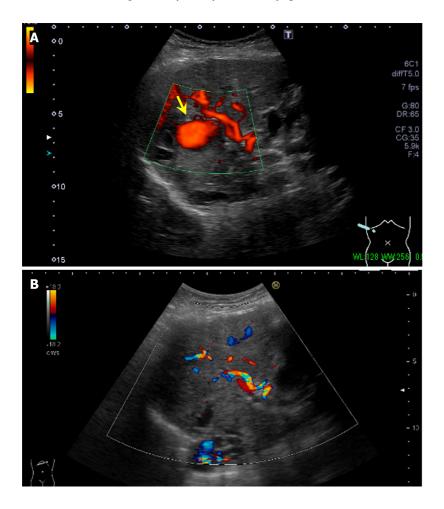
Abdominal ultrasonography. A: Abdominal ultrasonography before aneurysm embolization. A mass lesion at hepatic S 7/8 showing pulsating blood flow (yellow arrow) was diagnosed as a hepatic artery aneurysm; B: Abdominal ultrasonography after aneurysm embolization. The intrahepatic artery aneurysm seen before aneurysm embolization had disappeared.
